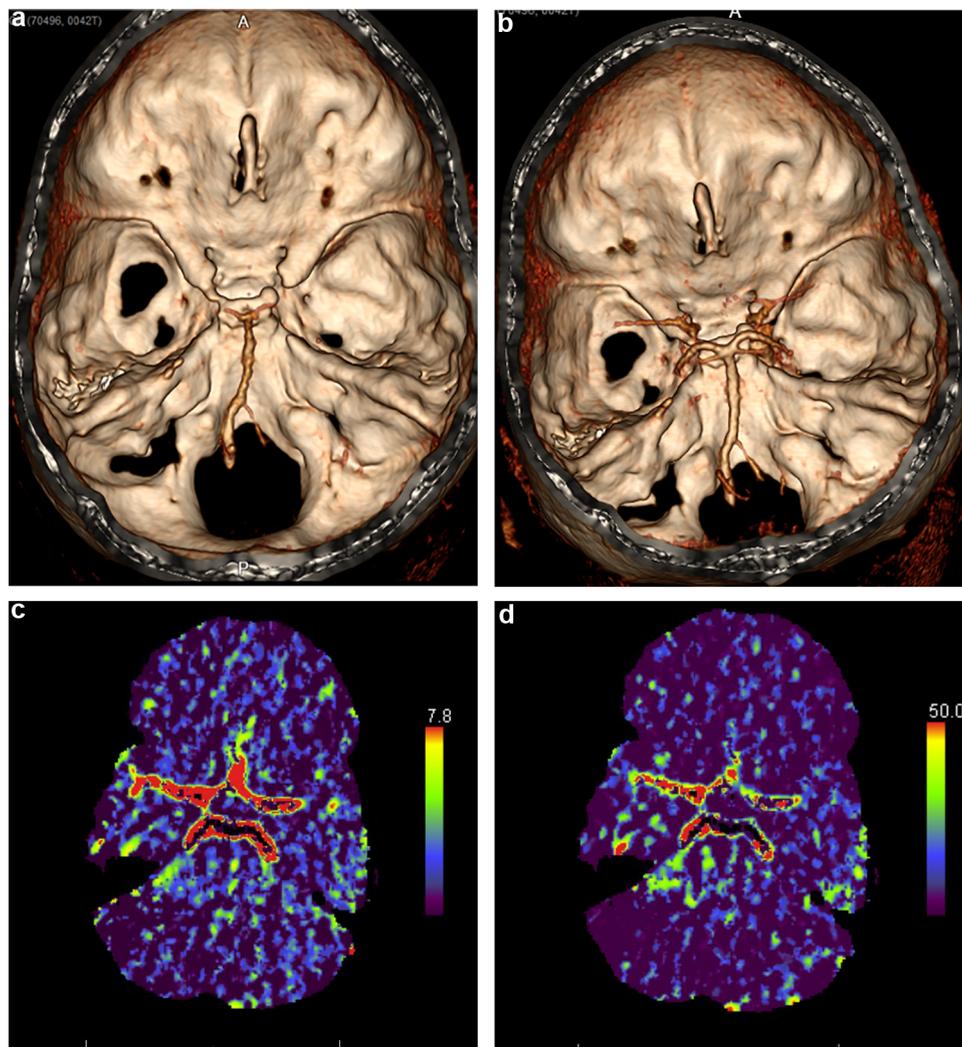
42-year-old female with brain death. Presented with diffuse subarachnoid hemorrhage. (a, b) Axial 3D multiphase CTA images demonstrate delayed opacification of intracranial circulation (a: 24 sec, b: 43 sec after contrast injection). (c,d) CT perfusion images demonstrate matched and decreased CBV (c) and CBF (d) in the supratentorium and posterior fossa including the brain stem.
